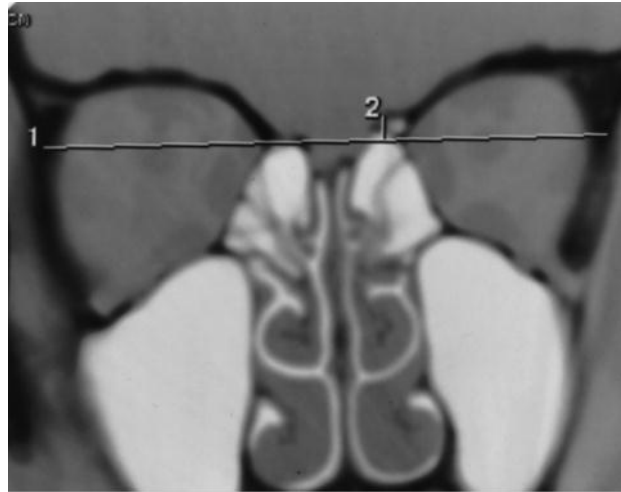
Coronal CT scan demonstrates a 2 mm height differential between the right (lower) and left fovea.
